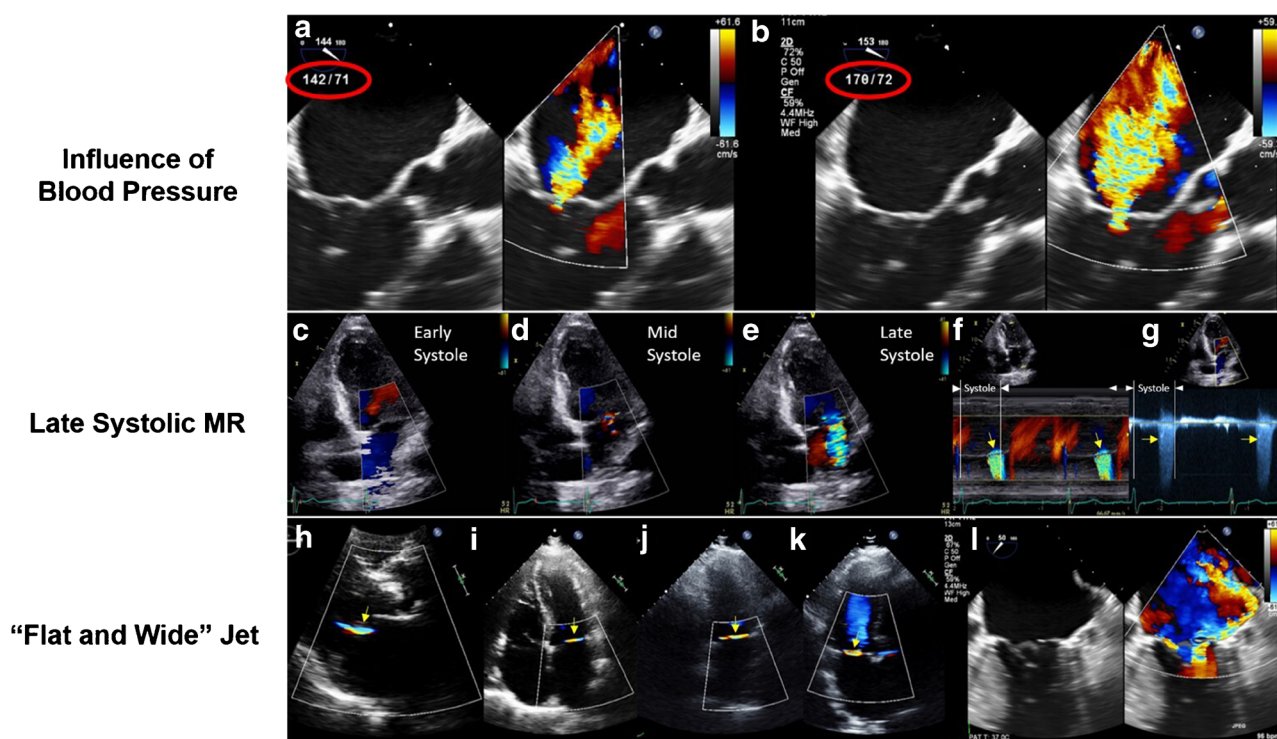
Common color Doppler pitfalls in assessment of MR severity. Color Doppler is helpful to detect MR presence but is not reliable as a sole method to determine MR severity. The size of the regurgitant jet on color Doppler can be influenced by systemic blood pressure at the time of image acquisition—higher blood pressure increases the momentum of the regurgitant jet leading to entrainment of non-regurgitant blood in the LA thereby increasing the color Doppler jet area (a, b). Inappropriate settings (low Nyquist limit, increased color gain, decreased transducer frequency, etc.) can artificially increase color jet area by emphasizing low velocity flow. Mitral valve prolapse is frequently associated with non-holosystolic MR—predominantly in late systole (c–g, arrows) when prolapse is at its peak. Note that no significant MR is seen on color flow Doppler in early and mid-systole (c, d) until a prominent MR jet suddenly appears for a short time during late systole (f, g, arrows). Overall regurgitant volume is low because the flow is short lived. A “flat and wide” jet restricted to peri-annular region is usually caused by extremely eccentric jets (usually flail leaflet) and the misleadingly small (truncated) color flow jet area may lead to underestimation of MR severity on transthoracic echo (h–k). In such cases, a TEE can unmask leaflet pathology and reveal the full extent of the regurgitant jet (l).
